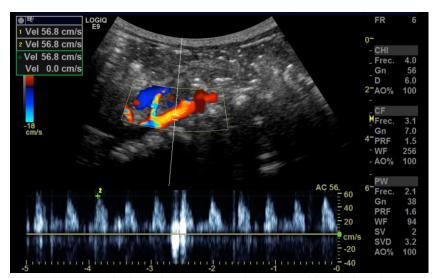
Vascular Doppler image of the descending aorta after catheter-directed thrombolysis showing normal flow
